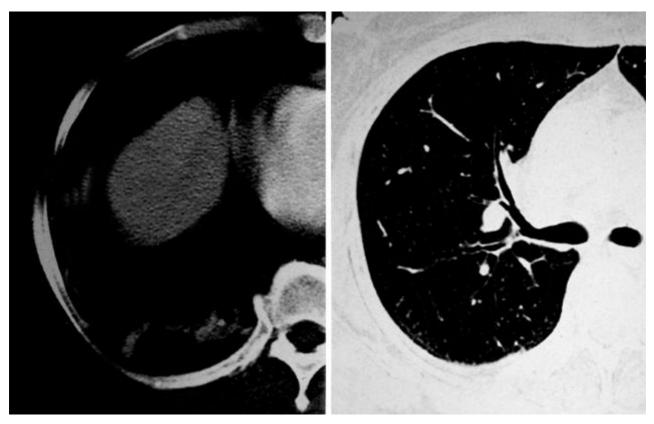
Axial CT scans in mediastinal and lung window settings show focal bronchial narrowing in the distal part of intermediate bronchus, obliteration of right lower lobe bronchus, air-space consolidation and plate like atelectasis in right lower lobe.
